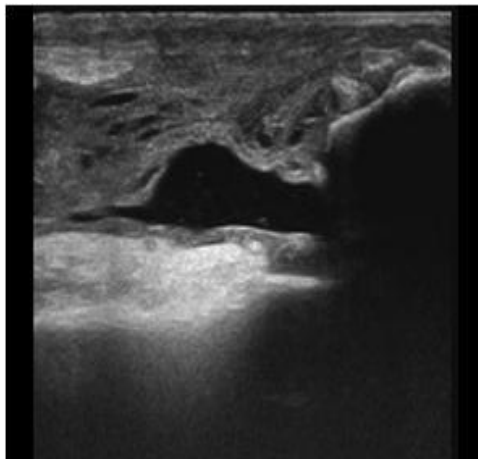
Knee joint Quadriceps tendon rupture, Ultrasound longitudinal view
